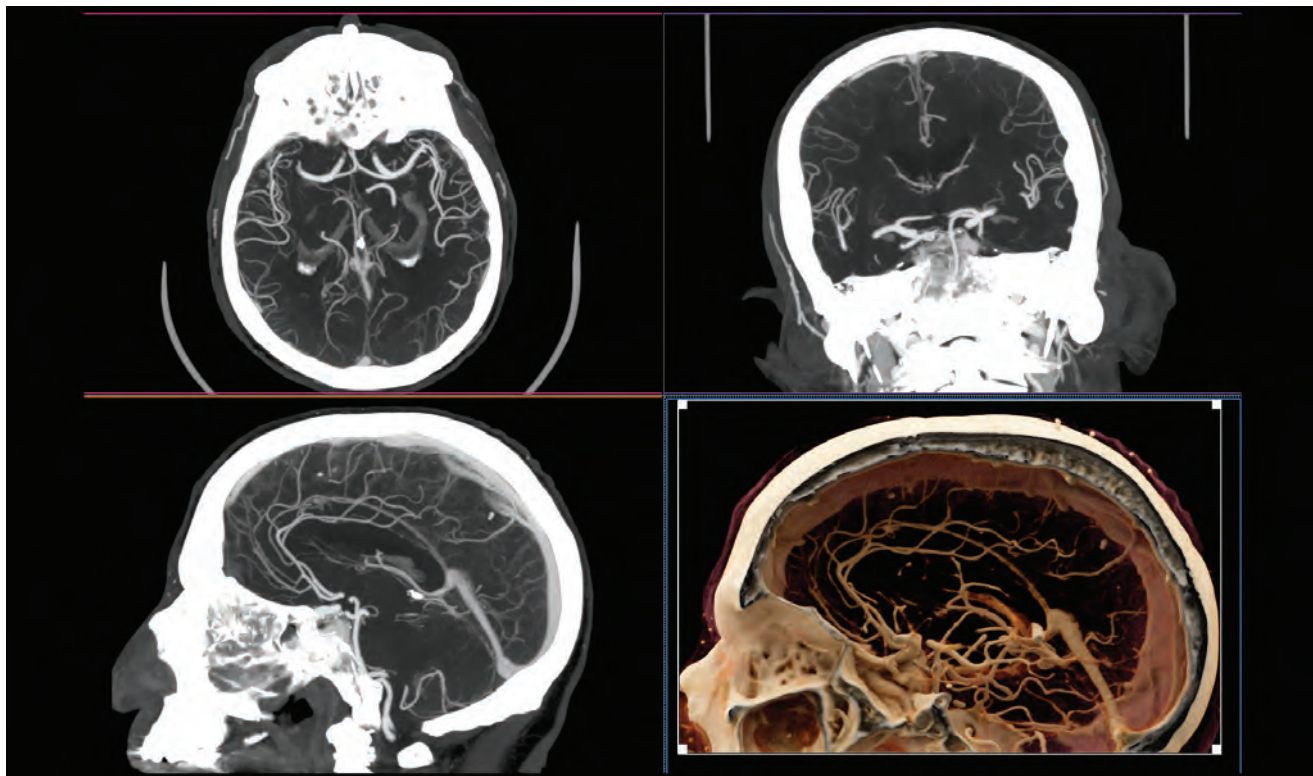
BLOOD VESSELS in the brain. Once referred to as CAT (computed axial tomography) scanners because the data were acquired and reconstructed in the axial plane, modern CT systems have submillimeter detector pixels along the z-axis of the patient. Those pixels enable high-resolution volumetric data acquisition and reconstruction. The three-dimensional data can be viewed as 2D images using axial (top left), coronal (top right), sagittal (bottom left), and volume-rendering techniques (bottom right). (Courtesy of Cynthia McCollough/Mayo Clinic.)
